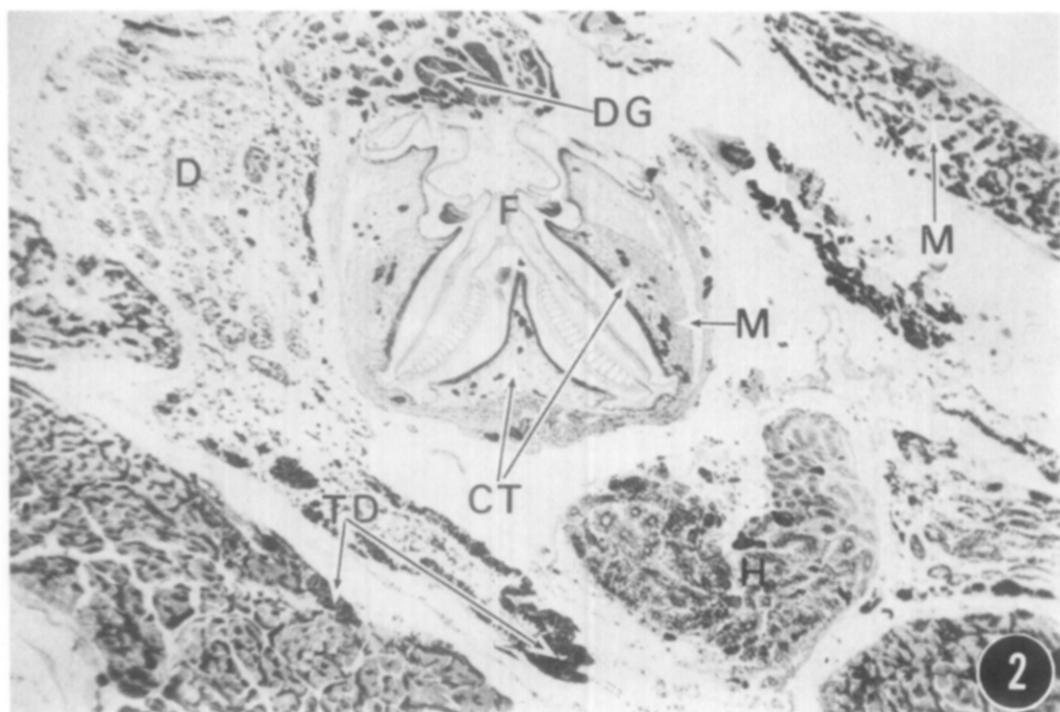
Cross section of thorax showing *Thelohania duorara* infection in thoracic muscles, in connective tissue and muscle lining the foregut, adjacent to the dorsal gland and digestive gland, and within the hemocyte-forming organ. CT, connective tissue; D, digestive gland; DG, dorsal gland; F, foregut; H, hemocyte-forming organ; M, muscle; TD, *Thelohania duorara* spores. $\times 45$.
